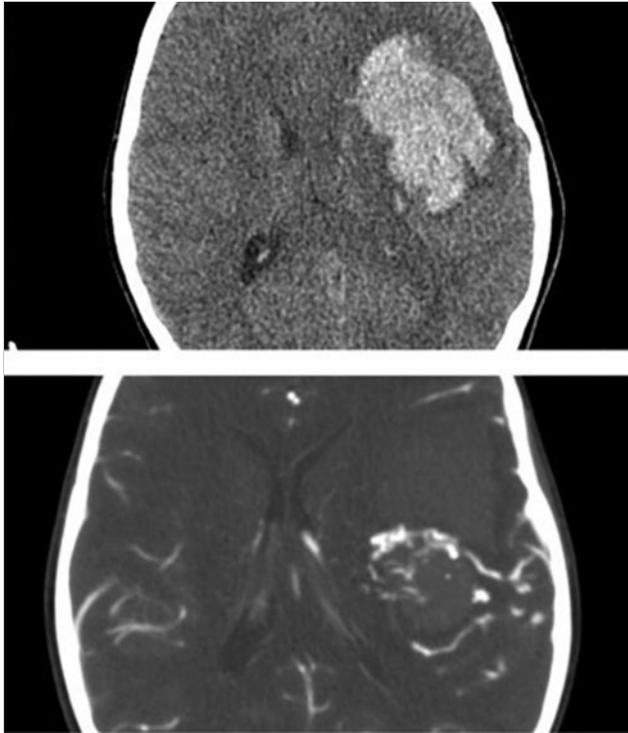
Utility of computed tomographic (CT) angiography in an emergent setting. Upper image is a noncontrast axial CT scan showing a large left frontal hemorrhage. Lower image is a CT angiogram of the same patient revealing the relationship of an arteriovenous malformation to clot and serving to increase the safety of emergent clot removal.
